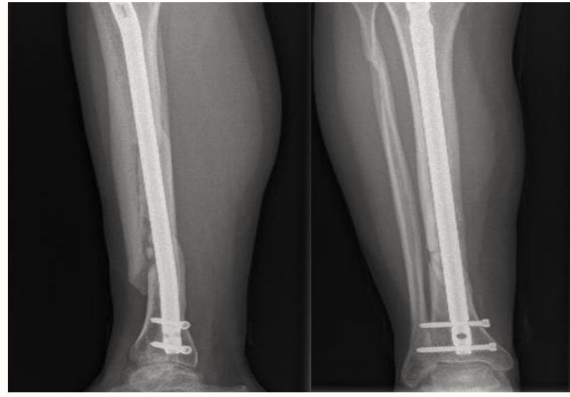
X-Ray shows Pseudarthrosis of the leg
